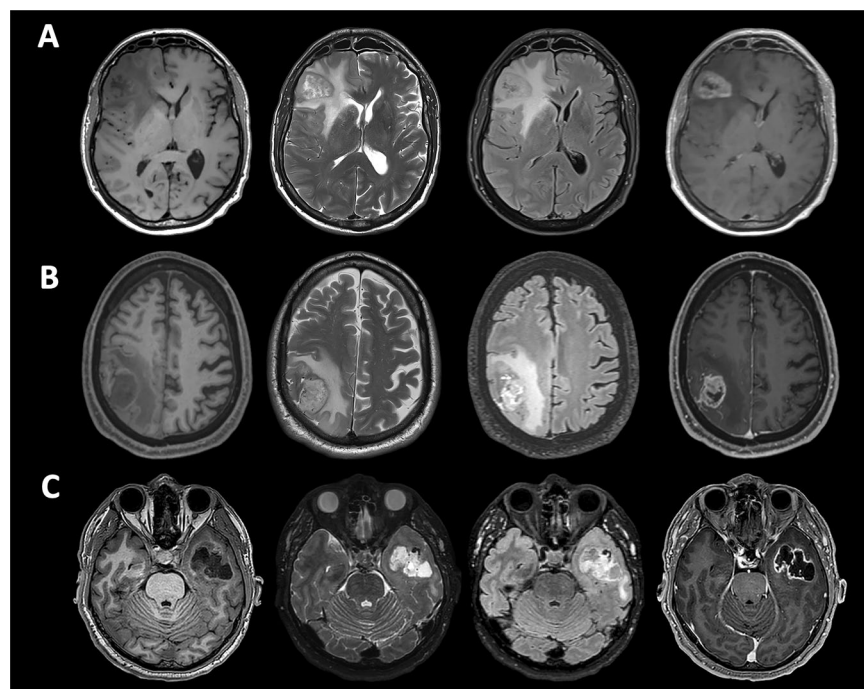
An example of raw MRI data from the three centers with the highest number of cases. (A) – IRCCS Istituto delle Scienze Neurologiche di Bologna, Italy; (B) – Städtisches Klinikum Karlsruhe, Karlsruhe, Germany; (C) – Novosibirsk Federal Neurosurgery Center, Russia.
